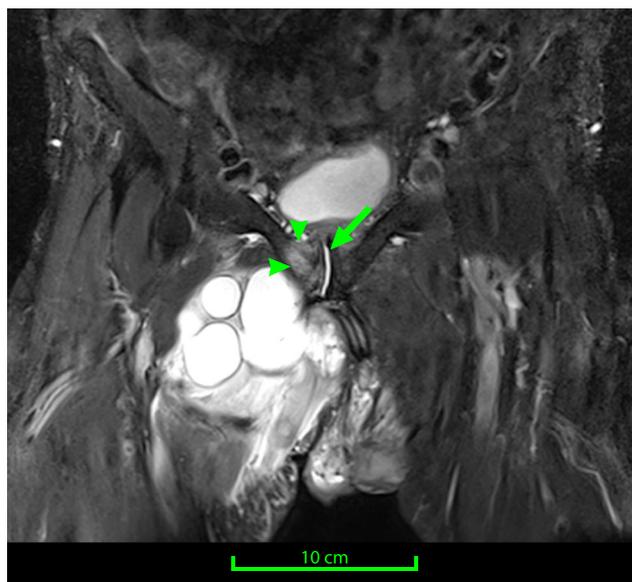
Follow-up MRI 6 weeks after the initial MRI and 5 weeks after biopsy demonstrates persistent parasymphyseal bone marrow edema (*arrowheads*) and a fluid-collection in the interpubic gap (*arrow*; coronal STIR)
